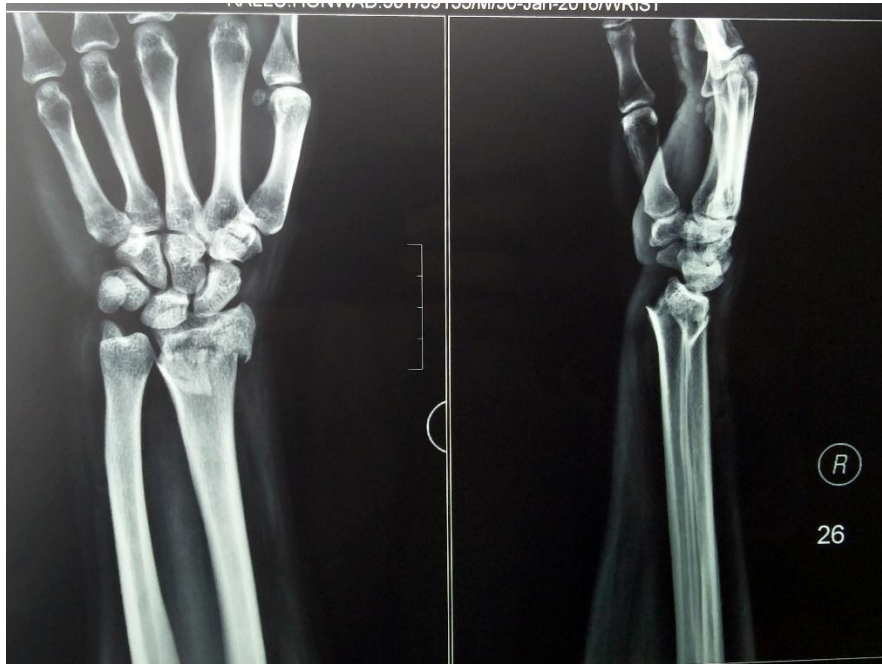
PREOPERATIVE XRAY
